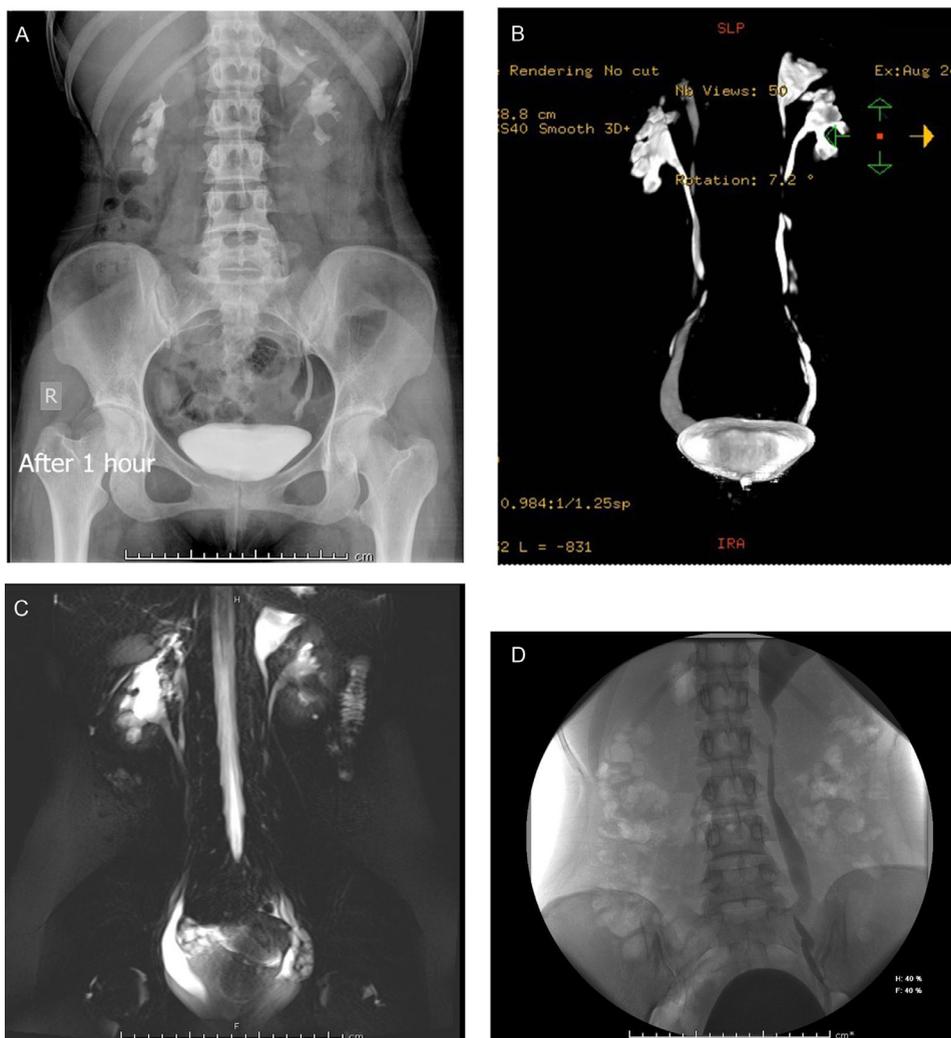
Pre-operative images. (A) Intravenous pyelogram (IVP) showing duplex system on the left side. (B) Excretory phase of CT urogram showing bilateral duplex system with poorly excreting dysplastic right upper moiety. (C) MR Urogram showing bilateral duplex system with dilated lower end of upper moiety ureters of both sides. (D) MCUG image showing grade V vesico-ureteral reflux into the right upper moiety ureter. (Color version available online.)
